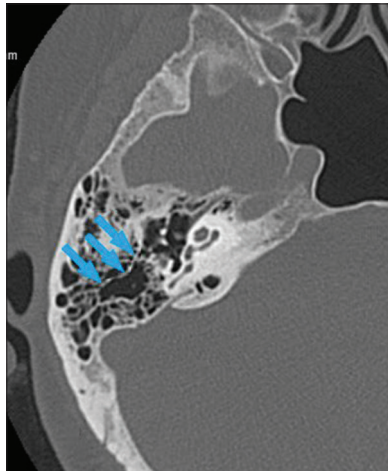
Körner's septum in temporal computed tomography taken in axial plane (blue arrow: Körner's septum)
